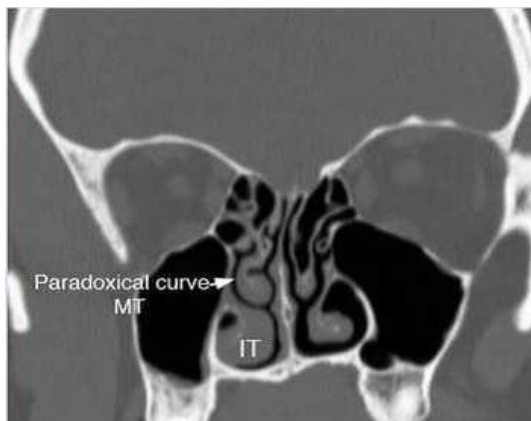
Coronal CT image showing paradoxical middle turbinate
